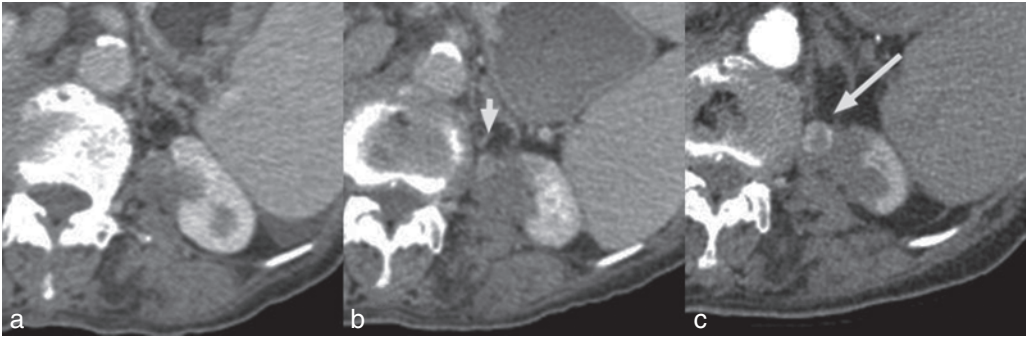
(a) Exophytic tumour prior to cryoablation. (b) Venous phase CT scan at 3 months demonstrates a heterogeneous hypodense area in the ablation zone with a curvilinear hyperattenuation area, or ‘halo’. (c) At 12 months, ablated lesion shows non-enhancement but persistence of the curvilinear hyperattenuation in the surrounding perinephric fat.
